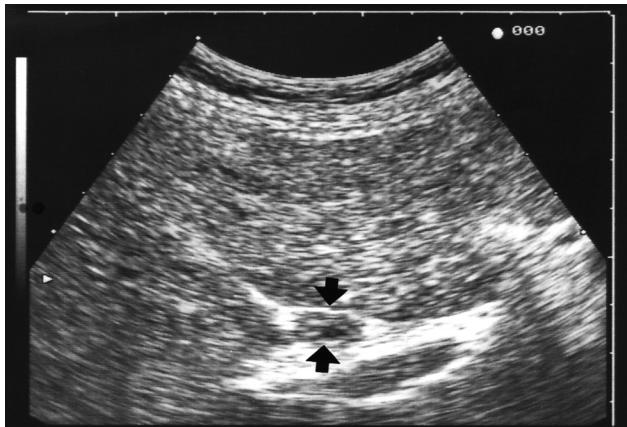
Transverse sonogram of the common bile duct showing thickened wall (arrows).
